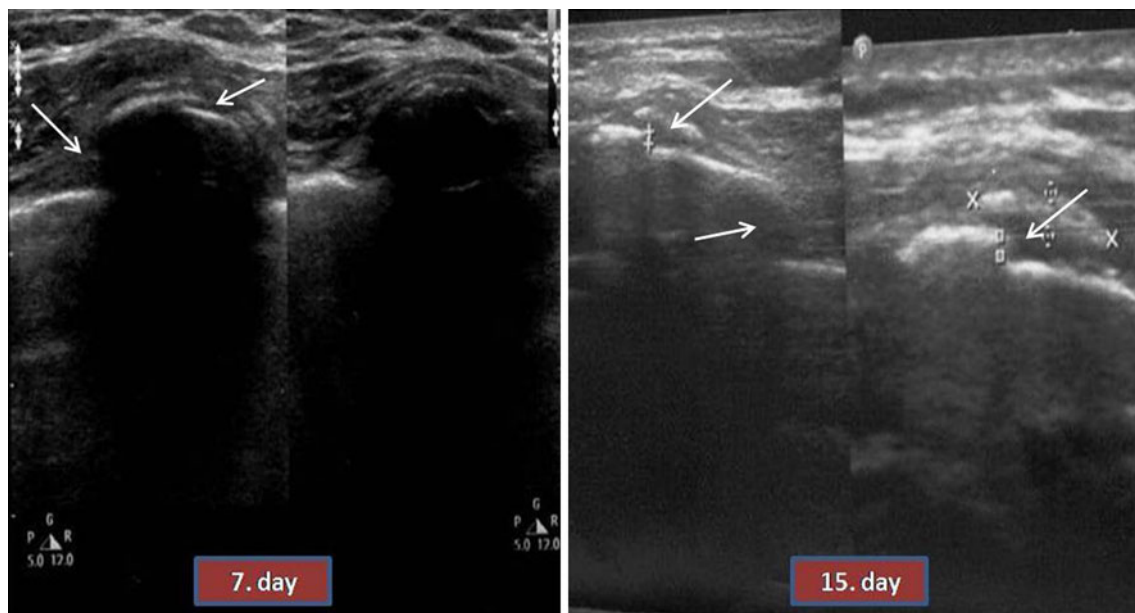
Days 7 and 15 ultrasonographic images of a fracture
